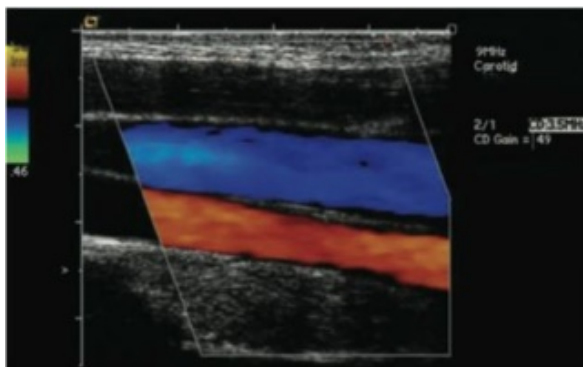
Doppler shift – color flow mapping.
